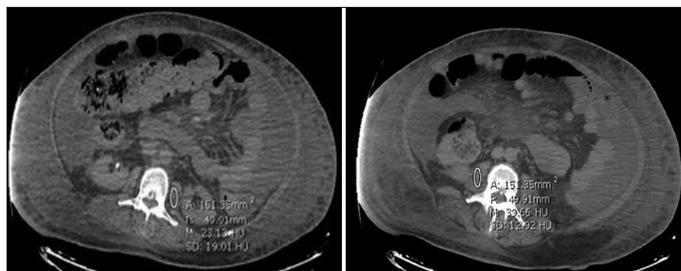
Computed tomography images used for the assessment of skeletal muscle density of the psoas muscle.
